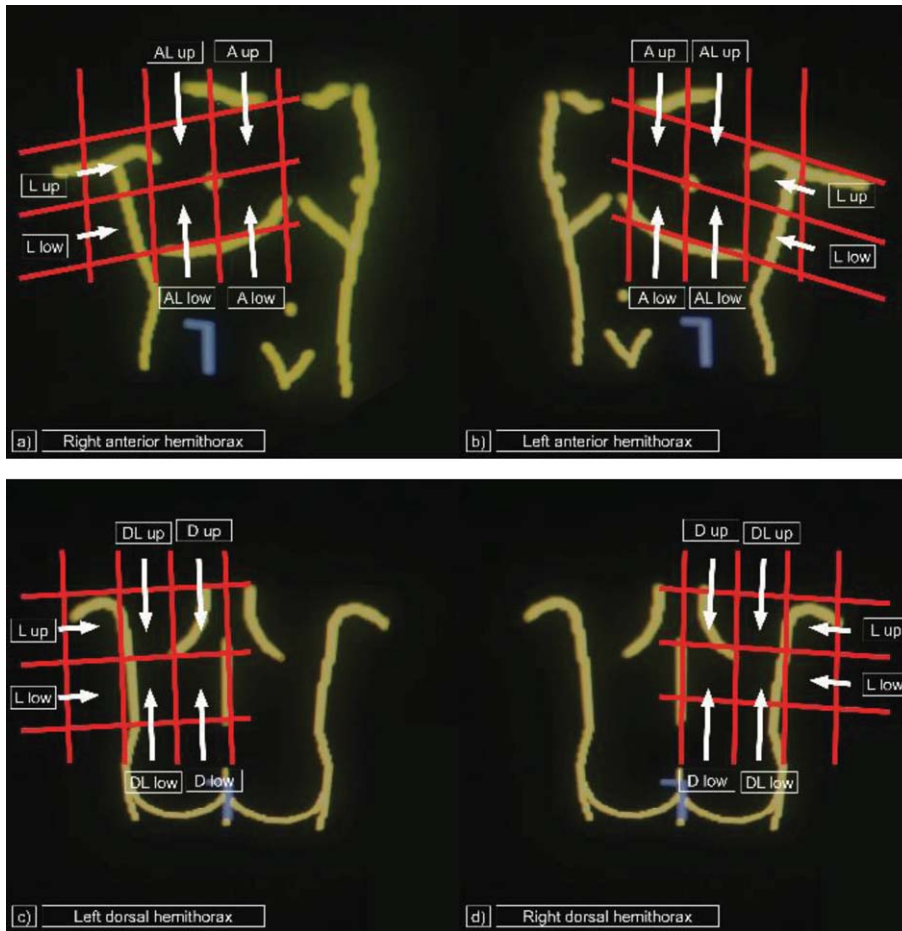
Areas examined by lung ultrasound. Twelve-area-examination with a convex 1-5 MHz array probe by bed side point-of-care lung ultrasound. a) Right anterior hemithorax: A up = anterior parasternal upper area, A low = anterior parasternal lower area, AL up = anterior lateral / para-axillary upper area, AL low = AL up = anterior lateral / para-axillary upper area, L up = lateral upper area, L low = lateral lower area. b) Left anterior hemithorax: A up = anterior parasternal upper area, A low = anterior parasternal lower area, AL up = anterior lateral / para-axillary upper area, AL up = anterior lateral / para-axillary upper area, L up = lateral upper area, L low = lateral lower area. c) Left dorsal hemithorax: D up = dorsal posterior paravertebral upper area, D low = dorsal posterior paravertebral lower area, DL up = dorsal lateral / dorsal para-axillary upper area, DL low = dorsal lateral / dorsal para-axillary lower area, L up = lateral upper area, L low = lateral lower area. d) Right dorsal hemithorax: D up = dorsal posterior paravertebral upper area, D low = dorsal posterior paravertebral lower area, DL up = dorsal lateral / dorsal para-axillary upper area, DL low = dorsal lateral / dorsal para-axillary lower area, L up = lateral upper area, L low = lateral lower area.
